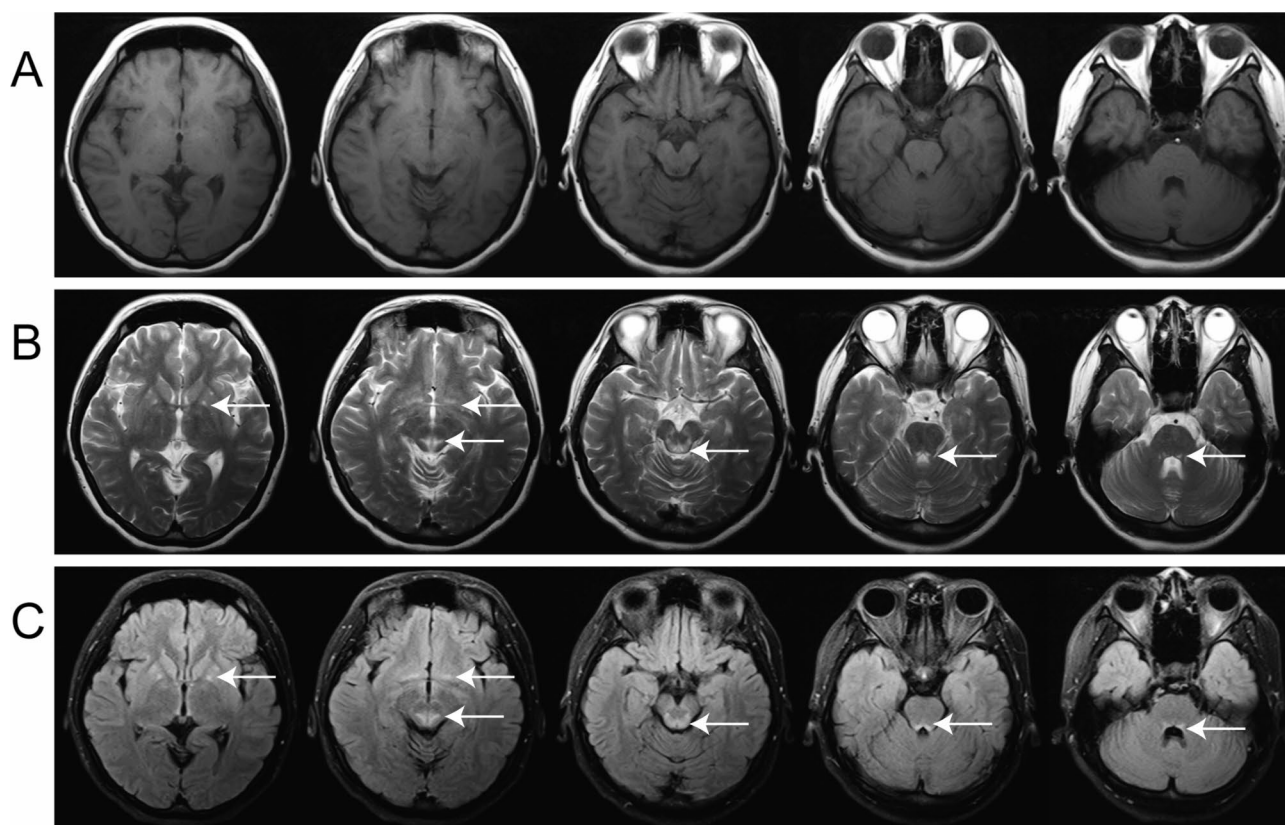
Compared with the previous images, the following lesions have been alleviated: cranial T1-weighted (A), T2-weighted (B) and FLAIR (C) MR images reveal bilateral symmetrical shrunk lesions with abnormal signals in the dorsal brainstem, mesencephalic aqueduct and bilateral basal ganglia
